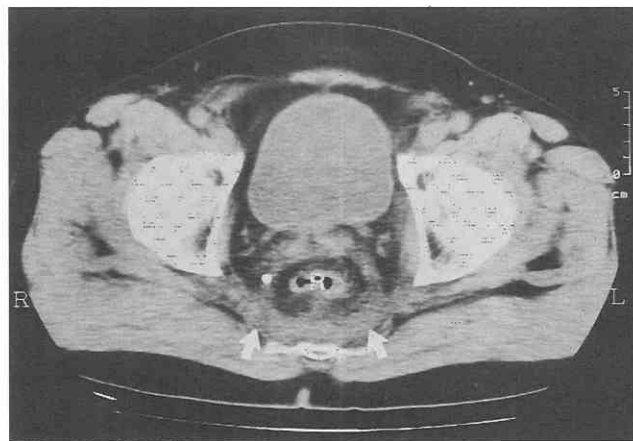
Postradiation changes. CT scan through the rectum (R) in a man who had previously undergone radiation therapy for prostate cancer. There is perirectal stranding and thickening of the presacral space (arrows).
